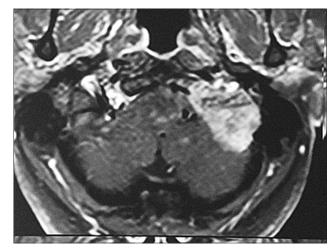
Magnetic resonance imaging brain with contrast confirmed a large left occipitotemporal bone tumor with lytic lesion
